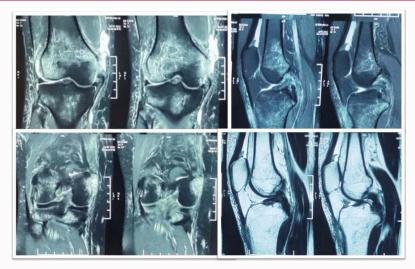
Preoperative MRI showing gross edema around the knee joint with a comminuted avulsion fracture of the medial condyle of femur, with a partial tear of Anterior Cruciate Ligament injury (ACL) on femoral attachment and intra-substance hyper-intensity with a complete tear of Posterior Cruciate Ligament (PCL) on its mid-substance with empty notch sign, and an avulsion of the Medial Collateral Ligament (MCL).
